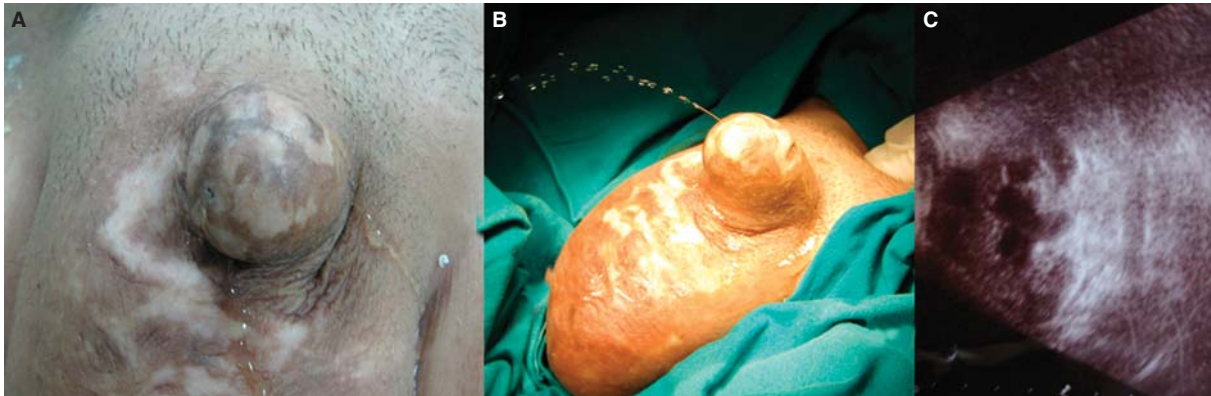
(A) Greyish white discoloration on the sclerotic foreskin and scrotum. Glans penis was concealed owing to severe phimosis. There were two pinpoint openings located ventrally and dorsally. (B) The patient was able to void by applying suprapubic pressure. A giant inguinal hernia sac was palpable in the scrotum (C) Severe to moderate hydroureteronephrosis was detected bilaterally by ultrasonography.
